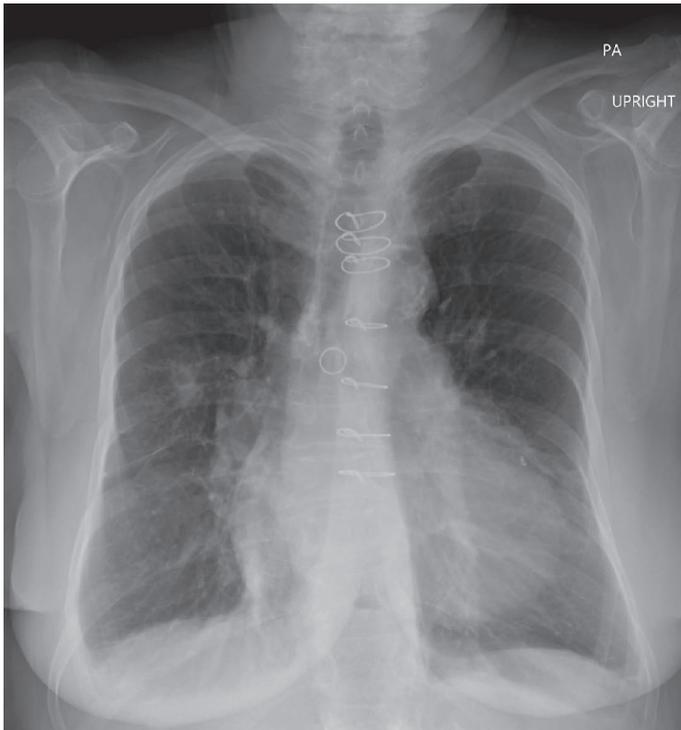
Posteroanterior chest X-ray showing bilateral hyperinflation with a spiculated right perihilar lung nodule.
